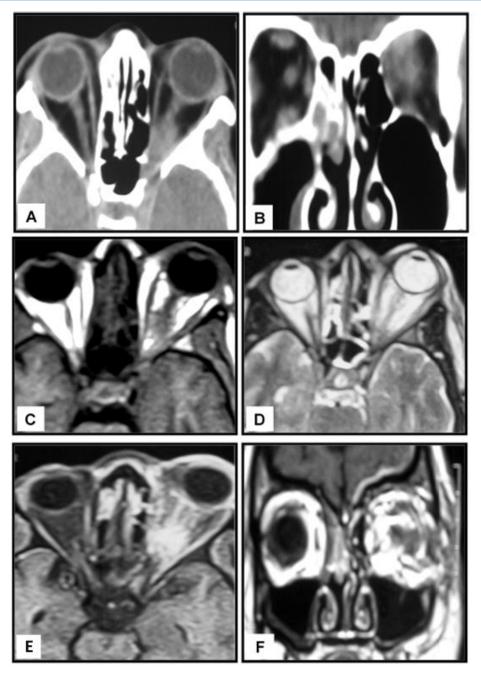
Leukemic infiltration of the left optic nerve. A 36-year-old female patient has a history of acute lymphoplastic leukemia (ALL), complaining of gradual diminution of vision and proptosis at the left eye. CT Examination: (A) and (B) Post-contrast axial and coronal cuts show a soft tissue density lesion involving the intraconal part of the left optic nerve with a widening of left optic foramen. MRI Examination: (C) Axial T1-WI of the same patient shows the lesion displaying hypointense signal and involving the intraconal and intracanalicular parts of the left optic nerve. (D) Axial T2-WI of the same patient shows a hypointense signal of the lesion. (E) and (F) Post-contrast axial and coronal T1-WI of the same patient reveal intense homogeneous post-contrast enhancement of the lesion with diffuse meningeal infiltration in the form of the enhanced thickened meningeal lining.
